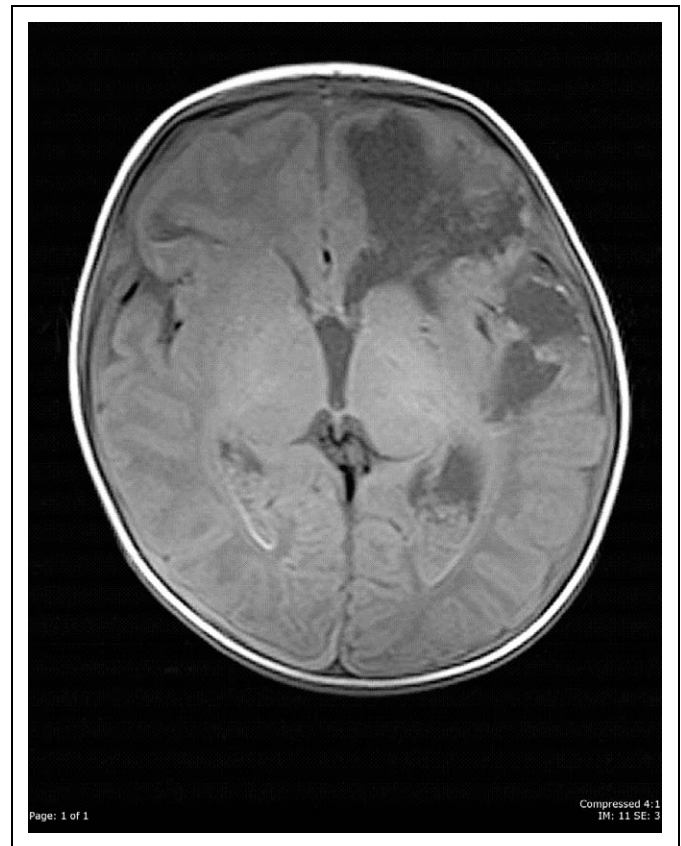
Case 2. Axial T1-weighted magnetic resonance imaging on day 2 of admission to the emergency department. Image shows pan-hemispheric bilateral subdural hematomas and extensive encephaloclastic lesions at the level of the frontal and temporal regions.
